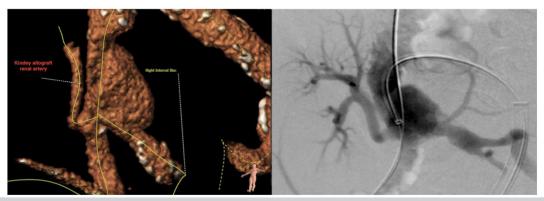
Incidental finding of a 4.8-cm right common iliac artery pseudoaneurysm located in close proximity to the kidney allograft and internal iliac artery on computed tomography (CT) and confirmed by angiography.
